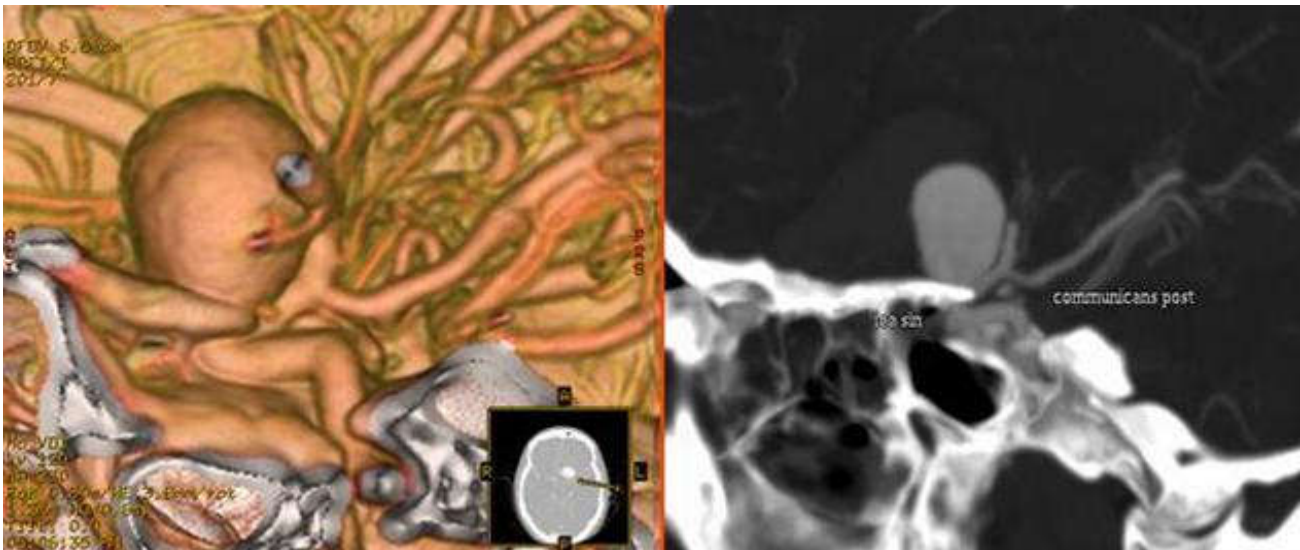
3D and 2D computed tomography angiography (CTA) showing the relationship between a left carotid-ophthalmic aneurysm and the anterior clinoid process.
